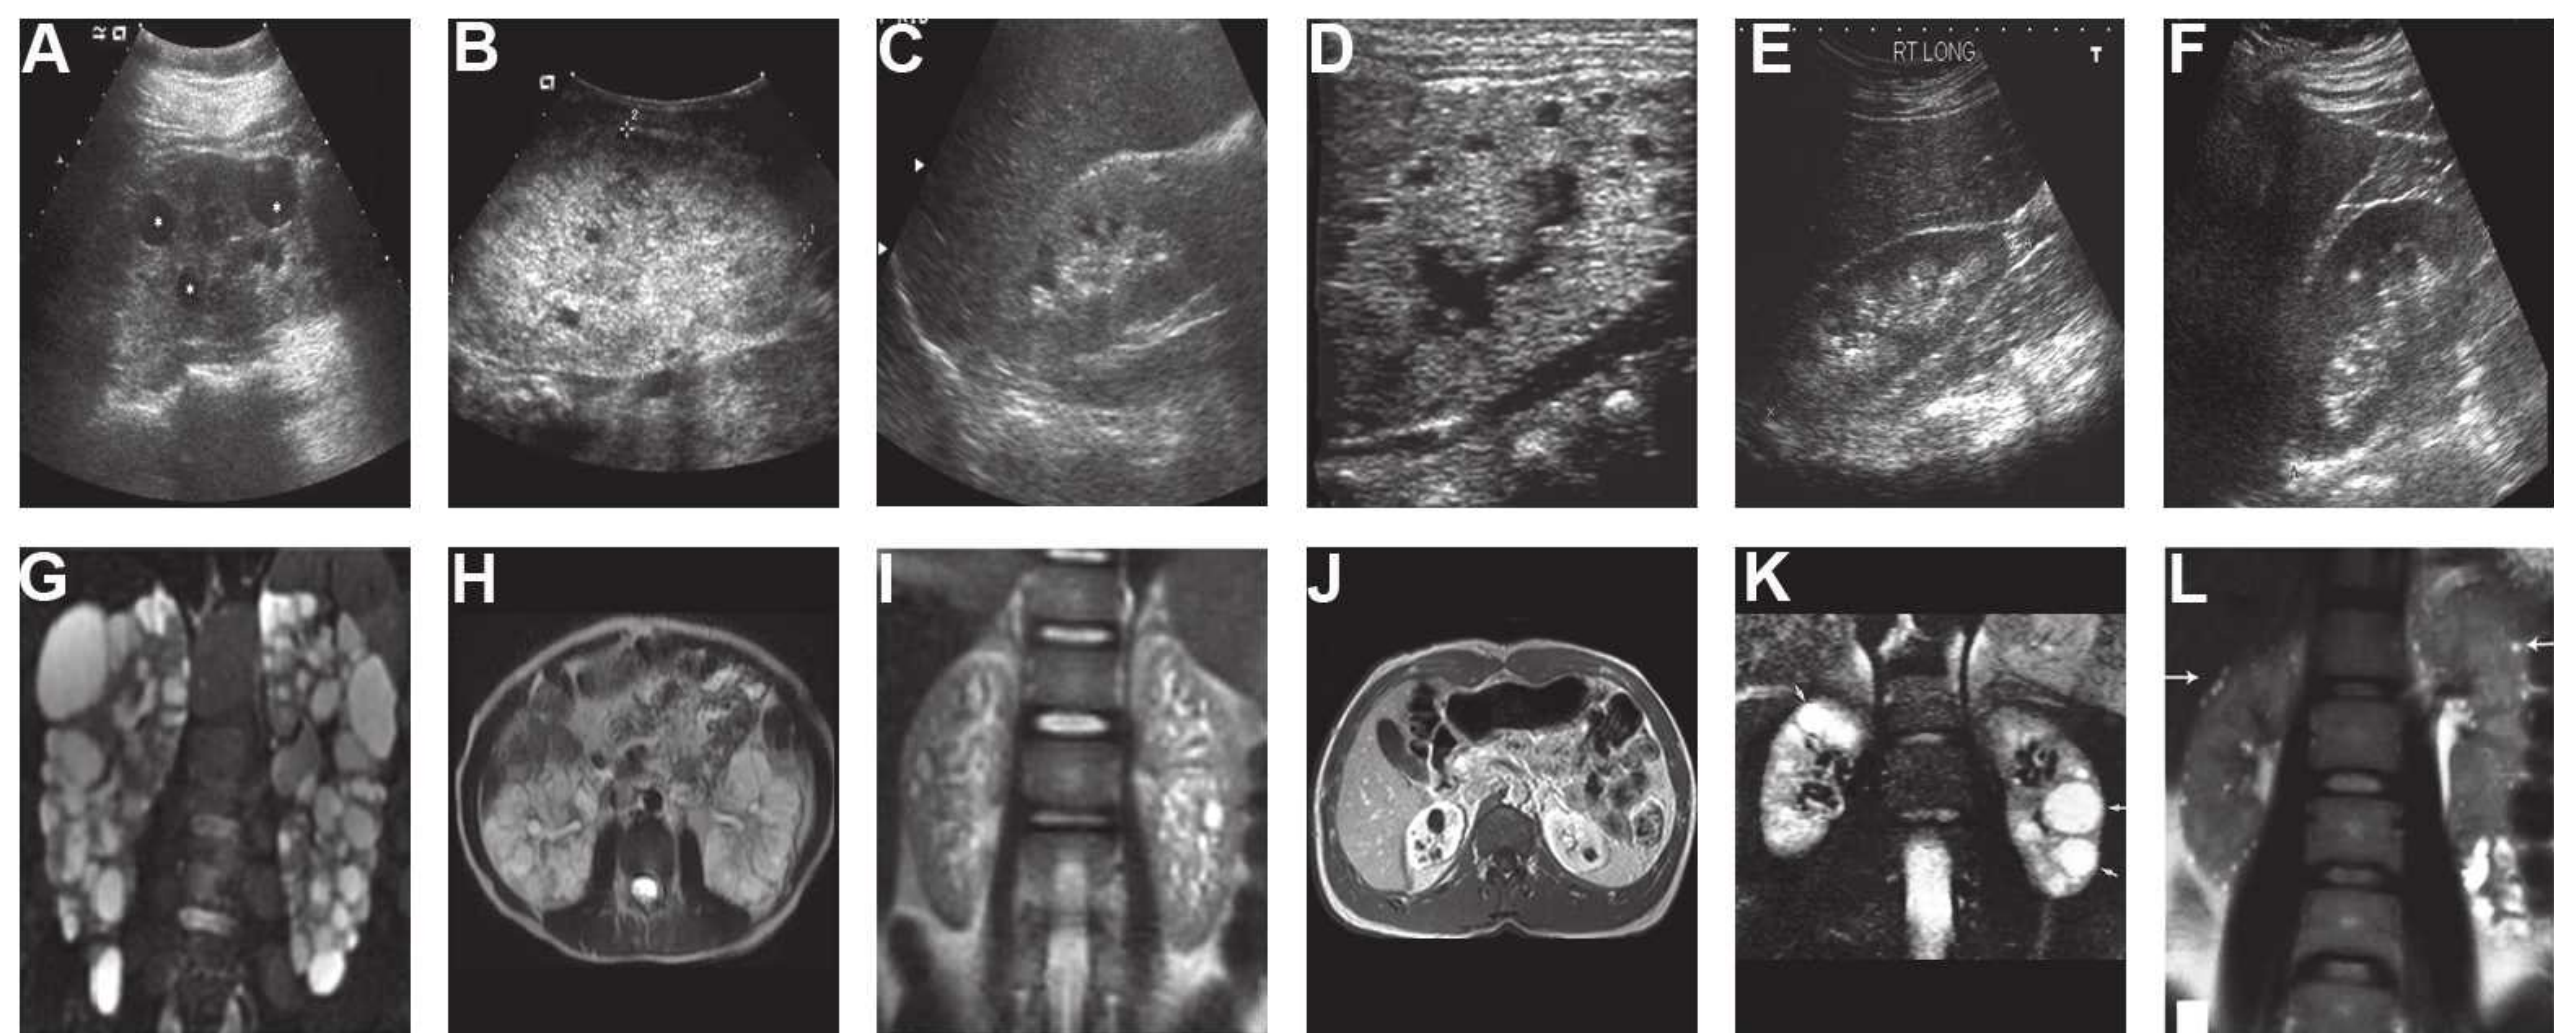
A radiographic appearance of hereditary renal cystic disorders. The top panels show ultrasonographic, longitudinal axis images of (A) autosomal dominant polycystic kidney disease (ADPKD), (B) autosomal recessive polycystic kidney disease (ARPKD), (C) familial juvenile nephronophthisis (NPHP), (D) glomerular cystic kidney disease (GCKD), (E) medullary cystic kidney disease (MCKD), and (F) tuberous sclerosis complex (TSC). The bottom panels show the same sequence of renal cystic disorders using either magnetic resonance imaging (MRI) or computed tomographic (CT) imaging: (G) a coronal MRI of early stage ADPKD, (H) an axial CT image of ARPKD, (I) a coronal MRI of NPHP, (J) an axial CT image of GCKD, (K) an axial CT image of MCKD, and (L) a coronal MRI of TSC.
